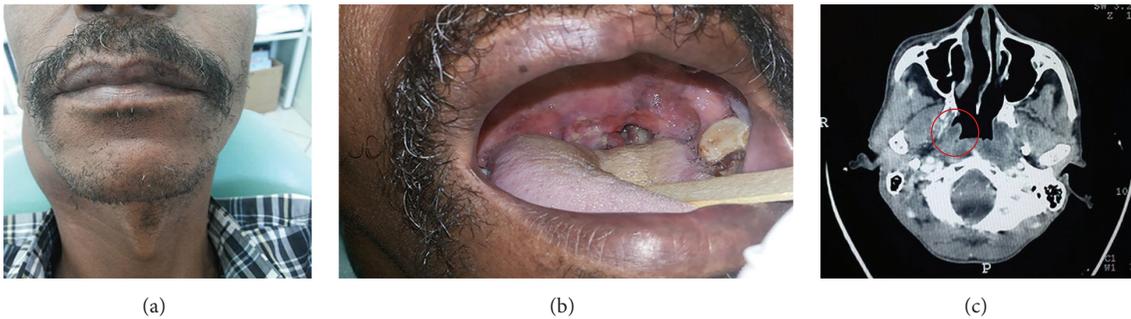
(a) The swelling on the right side of the neck, (b) ulcerated mass on the right palatine tonsil, and (c) CT image exhibiting a lobulated and ill-defined lesion (red circle).
